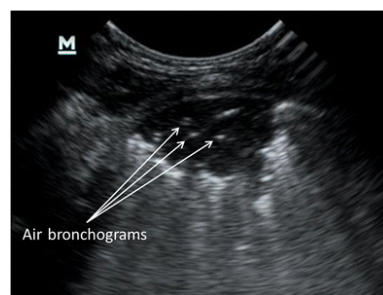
C : Pathologic Ultrasound: note the Air Bronchoagrams
